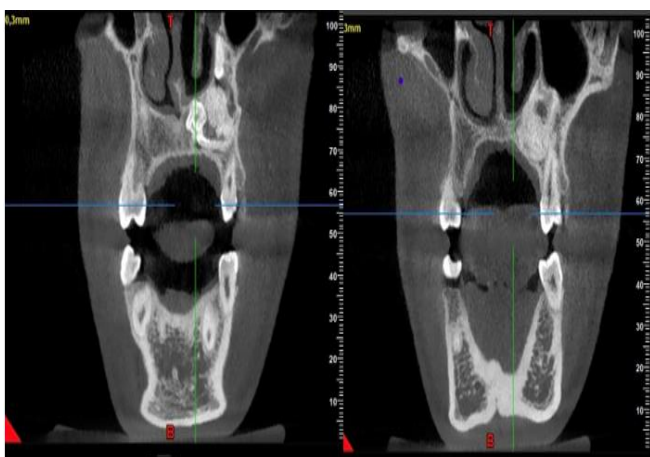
3-dimensional computed tomography image.
